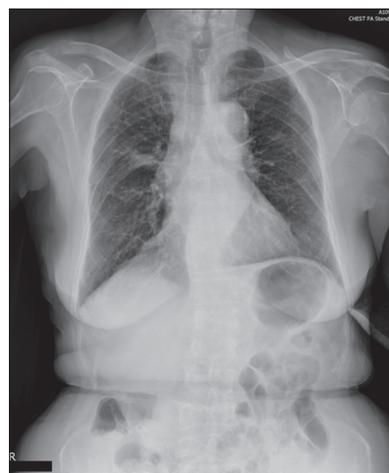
Chest radiography showed a nodular patch over right upper lobe
